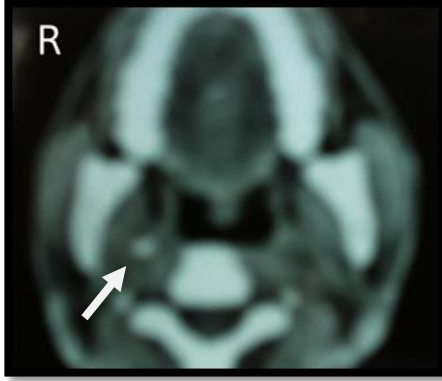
CT scan of the neck showing unilateral elongated styloid process on the right side. (arrow).
